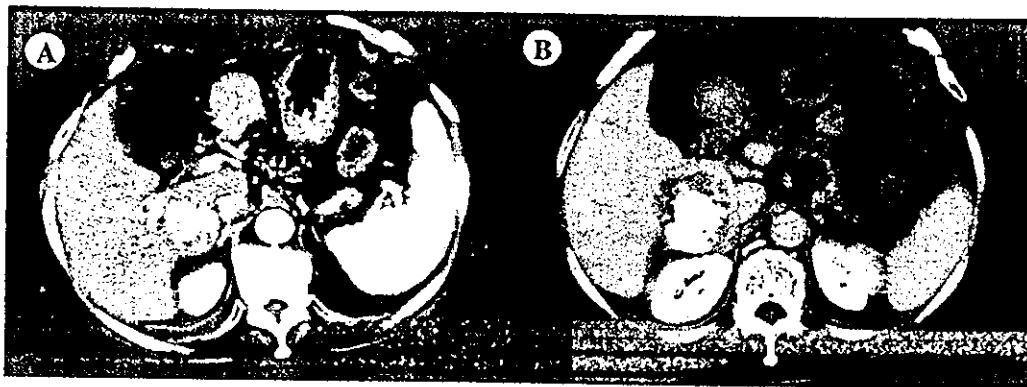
Contrast-enhanced dynamic CT before (A, early phase) and after (B, late phase) for HCC (4 cm) located in the S5 region of the liver of case no. 1. HCC was located close to the right kidney. The tumor showed the clear early enhancement. PELI-RFA was performed at 50 W for 4 min and 70 W for 20 min after injecting 15 ml of the mixture of ethanol and lipiodol. The safety margin area around the tumor region was visible after the treatment.
